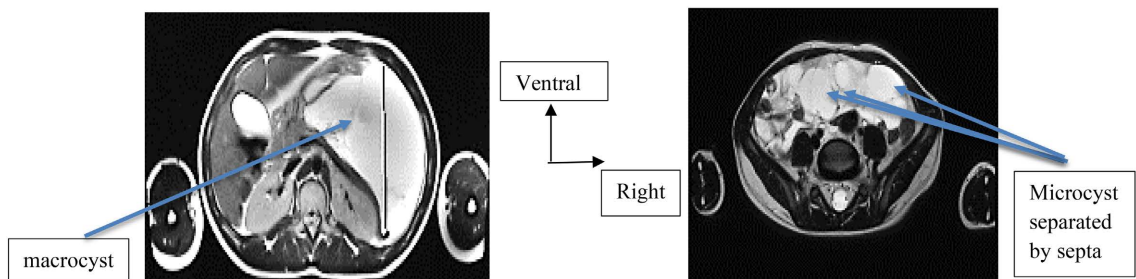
MRI of an abdominal cystic lymphangioma: macrocyst (left) and microcyst (right).
